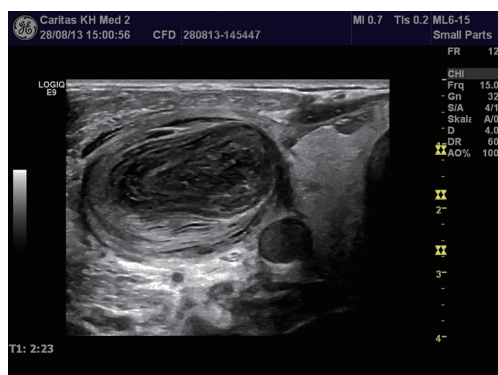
Ultrasound image of thrombosis of the right internal jugular vein.
